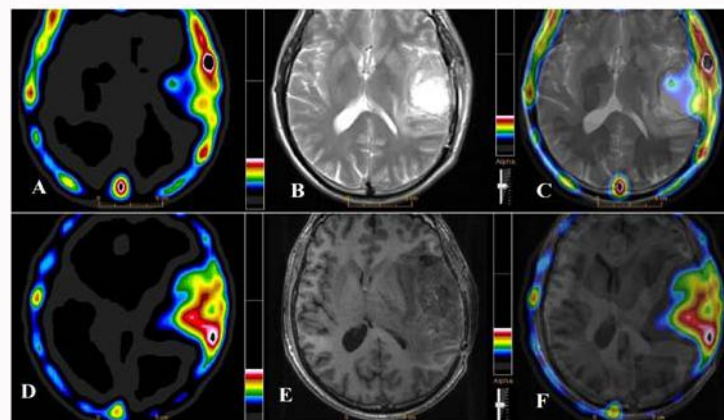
An increased uptake of ^{99m}Tc-MDM on SPECT image (A) in a 48 years old male GBM patient, contrast enhancement on CE-MR and fused SPECT/MR images (B & C) shown post surgical/chemo-radiotherapy (at 3-months) residual disease in the left temporal lobe. The subsequent SPECT (D), DSCE MR (E) and fused SPECT/MR images at 6-months follow-up indicated a significant disease progression in the corresponding region of the brain.
